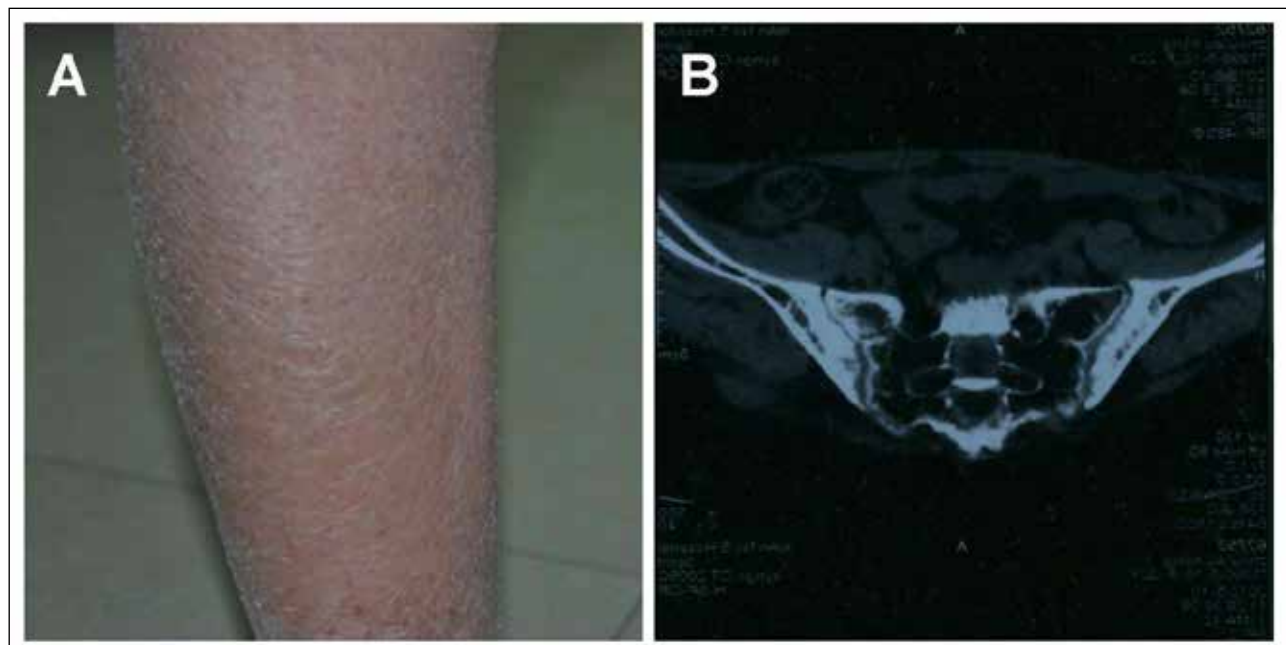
Physical features of the patient. (A) Skin manifestation. Off-white scaling is clearly visible on the lower limbs. (B) Computed tomography scan of the bilateral sacroiliac joints.
